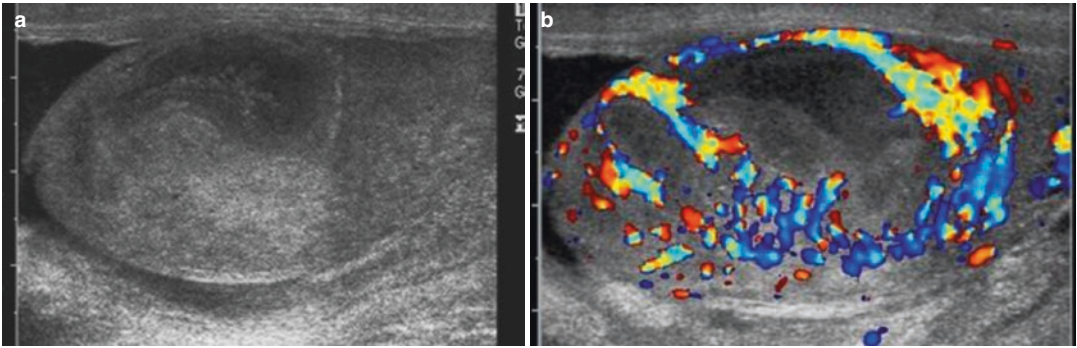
(a, b) Epididymo-orchitis can become abscesses; in this case, the colour Doppler examination shows the absence of flow into the lesions with increased flows in the outer margins
